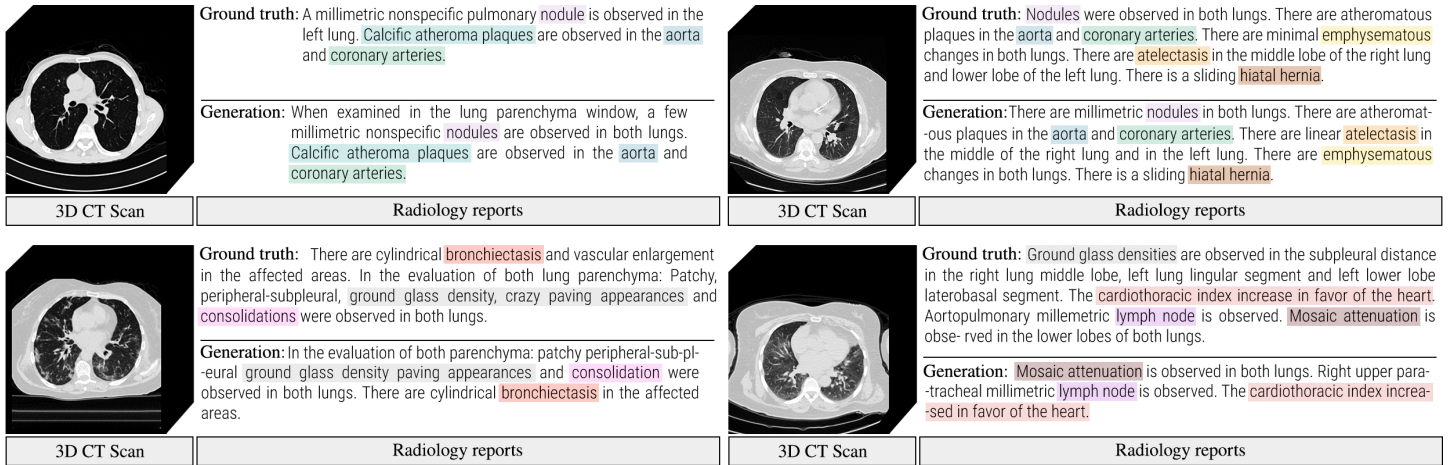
Qualitative comparison between ground-truth reports and those generated with CT-SSG for 3D Chest CT volumes. Color-coded highlights indicate abnormalities correctly captured by the model, demonstrating alignment with ground-truth annotations.
